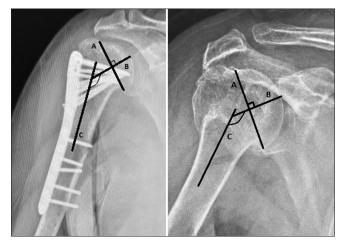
The measurement of the head shaft angle using the plain X-ray anteroposterior view. The angle between line B and line C represents the head shaft angle. A line: from the superior to the inferior border of the articular surface of the humerus. B line: perpendicular to the A line through the center of the humeral head. C line: line bisecting the humeral diaphysis
